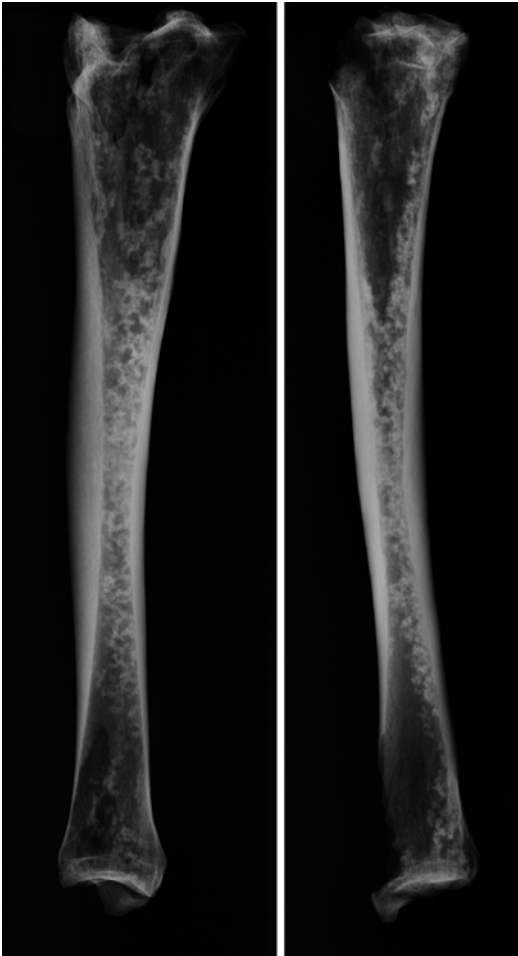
X-rays antero-posterior and lateral view: fracture of the tibial plateau. On the side is interesting to note diffuse hypodensity of the central part of the metaphysis is caused
